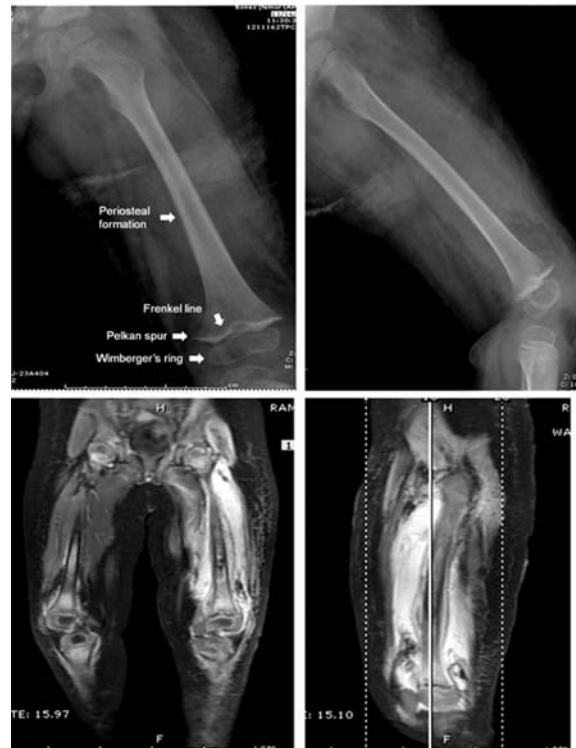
Above: the radiographs on the 4th day of admission showed soft tissue swelling, solid periosteal formation, Frankel line, Pelkan spurs, and Wimberger's ring at the left femur, Below: MRI demonstrated diffused marrow enhancement of bilateral pelvic bones, sacrums, femurs and tibias with subperiosteal abscess along the left thigh.
